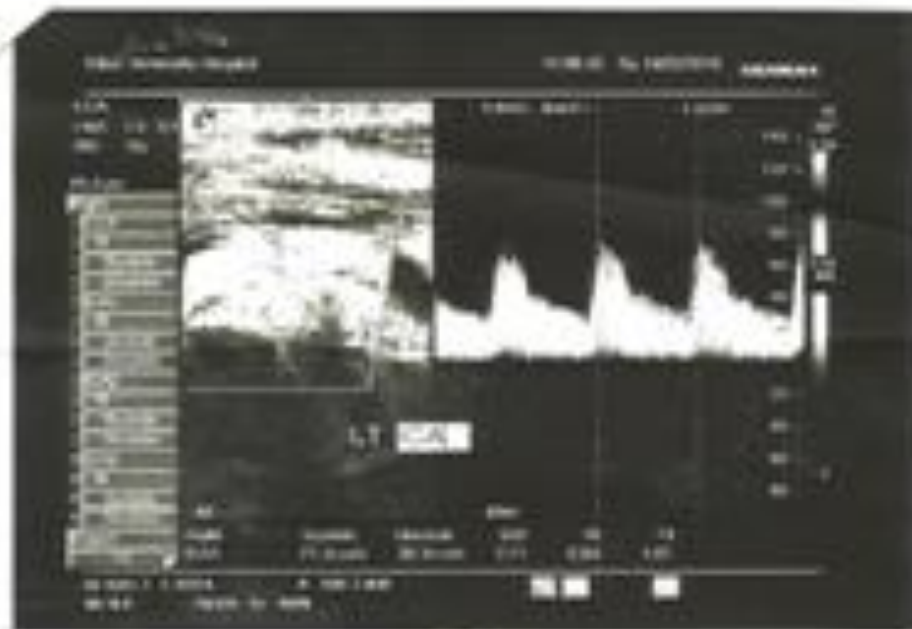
Lt CCA- male- 41 years diabetic patient with normal Doppler parameters.
